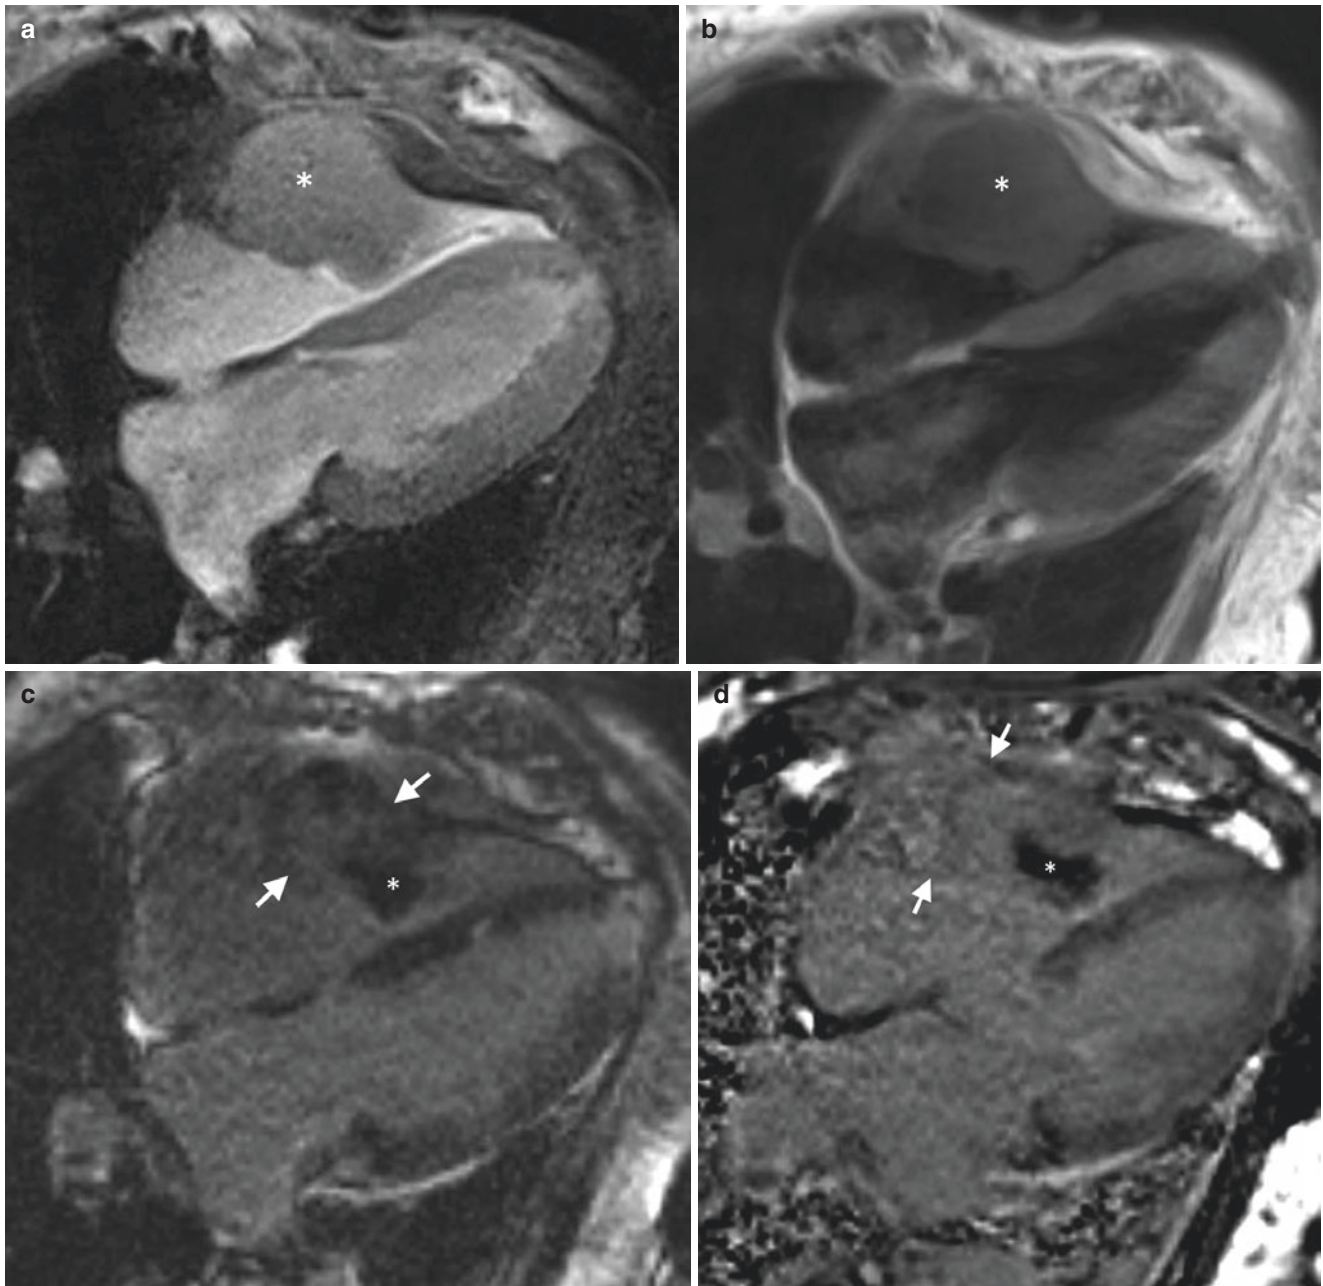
A 66-year-old female with factor V Leiden mutation and antiphospholipid syndrome was found to have a mass on echocardiography and thus referred for cardiac MR evaluation. (a) Steady-state free precession image, four-chamber view, demonstrates an isointense mass in the left atrium posterior wall. (b) T1-weighted double inversion recovery (DIR) image, short-axis view, demonstrates an isointense
